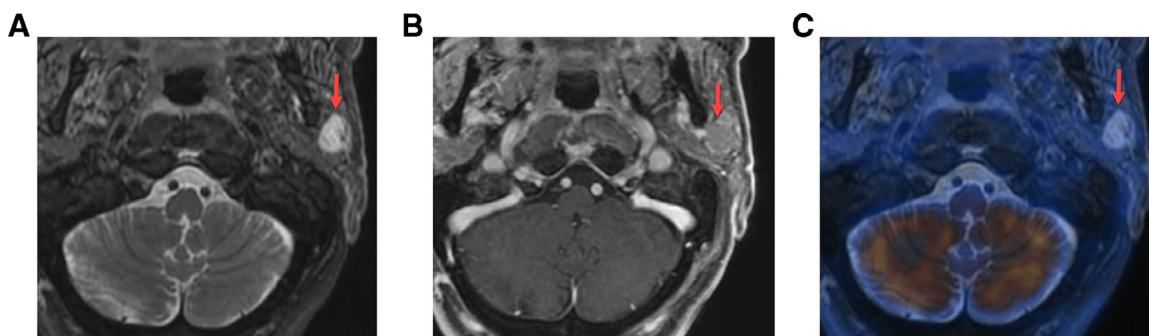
Acinic cell carcinoma of the parotid gland. The well-defined tumor (arrow) is T2w-hyperintense (A), enhances only little contrast medium if any (B) and is FDG-negative (C).
